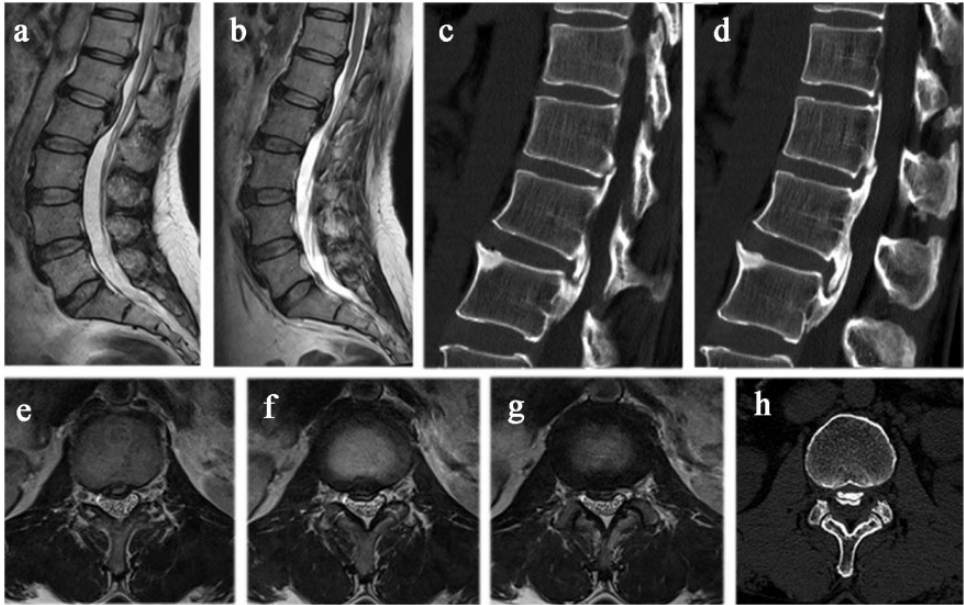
Imaging of the patient on admission. Preoperative (a, b) sagittal and (e–g) axial T2-weighted magnetic resonance images of the patient on presentation demonstrated localized ossification of the posterior longitudinal ligament (OPLL) at T12–L2, compressing the spinal cord. The OPLL at T12–L1 showed mild compression, while L1–L2 was severely compressed. (c, d) Sagittal and (h) axial computed tomography showed significant central stenosis of the spinal canal as well as OPLL extending from T12 to L2, being most prominent at the level of the inferior rim of the L1 pedicle–L2 pedicle.
